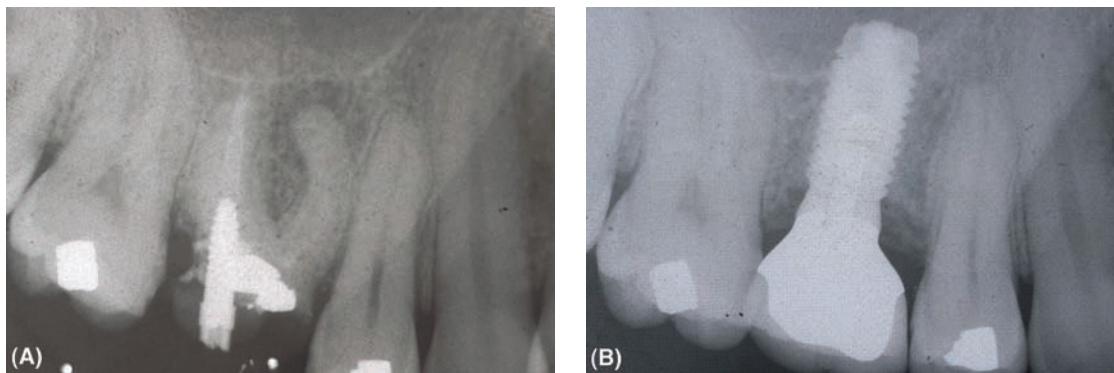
(A) Radiograph of a maxillary first molar with failed endodontic treatment and a broken down crown. The adjacent teeth have small restorations. (B) The first molar has been replaced by a single tooth implant: a 5-mm-diameter wide-platform Nobel Biocare. The implant is 10 mm in length and extends to the maxillary sinus.
